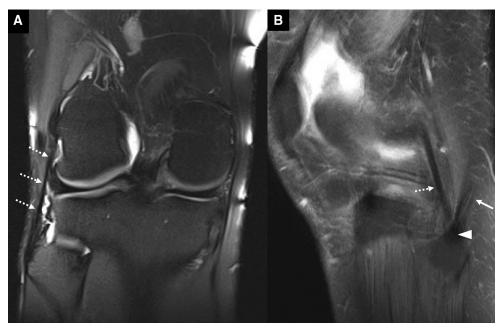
Fibular collateral ligament (FCL) at the lateral aspect of the knee shown on PD-w fat saturated magnetic resonance (MR) images. (A) Coronal MR image shows the FCL (dashed arrows), which is part of layer 3 of the posterolateral corner of the knee. The FCL attaches to the lateral femoral condyle proximally and upper facet of the fibular head distally. (B) Sagittal MR image at the level of the fibular head shows the FCL (dashed arrow) and biceps femoris tendon (solid arrow), which is part of layer 1, forming a conjoined tendon (arrowhead) about their fibular attachments.
